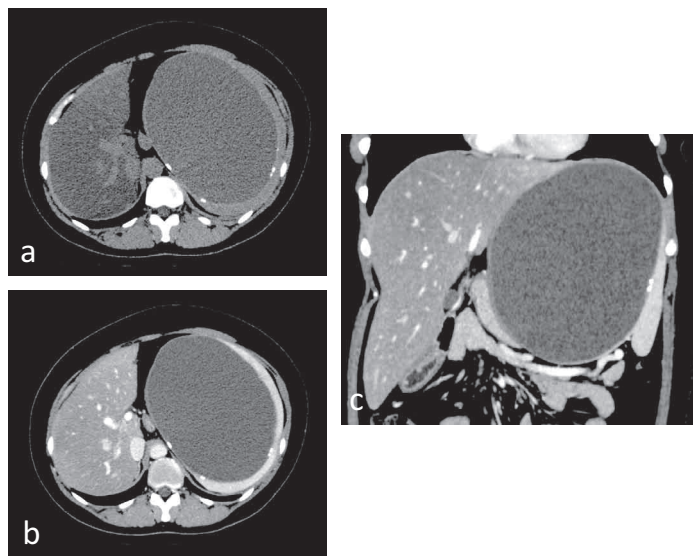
(a) : Abdominal CT also showed a huge cystic lesion in the hilus of the spleen and severe low density area was diffusely demonstrated in the liver. (b) : Enhanced image showed no nodule in the wall. (c) : Coronal view.
